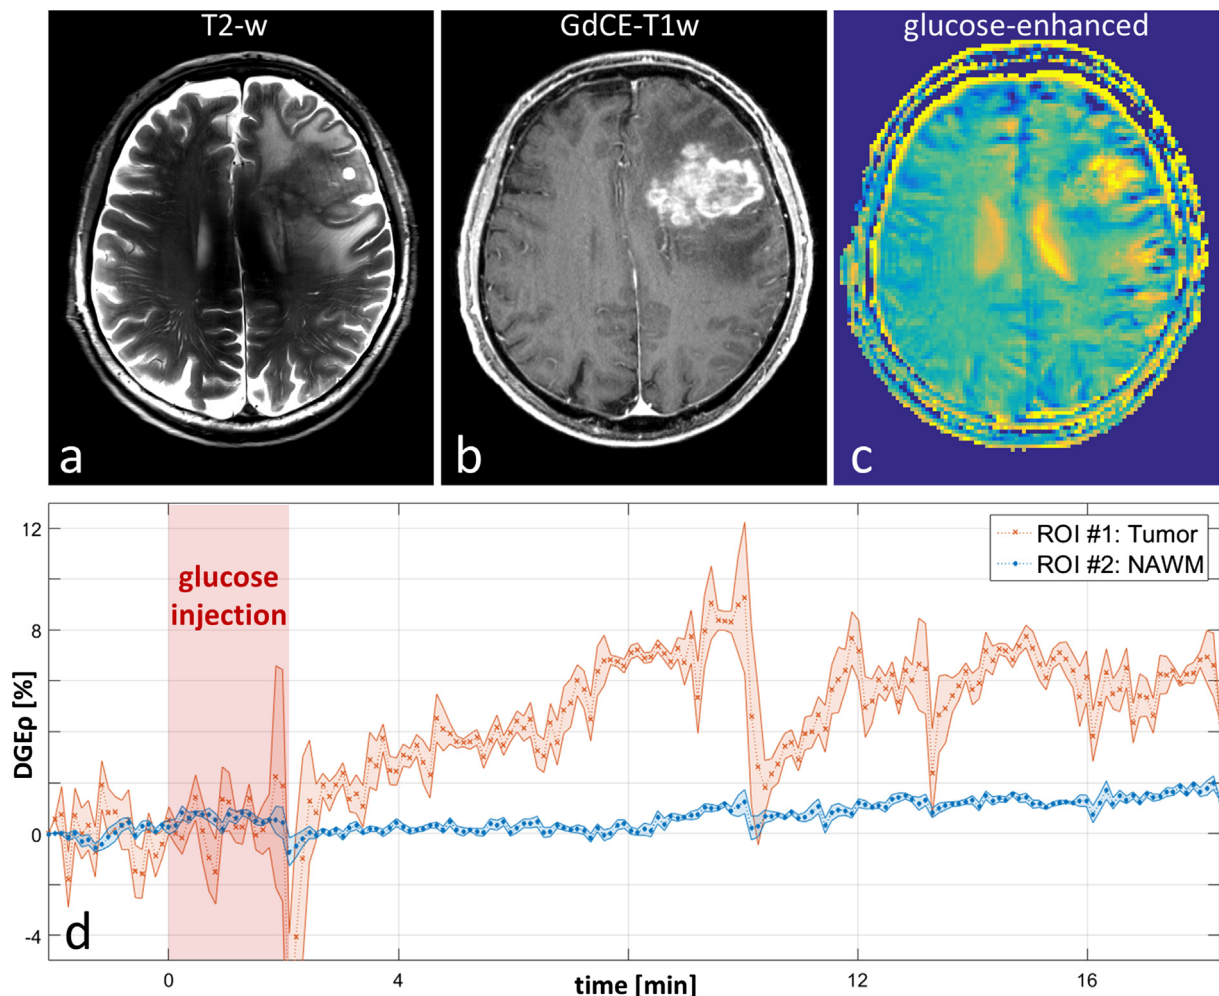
(a) T2-weighted image acquired at 7 T, (b) gadolinium-enhanced T1-weighted (GdCE-T1w) image acquired at 3 T, and (c) T1p-weighted dynamic glucose enhancement (DGEp) obtained at $t = 588$ s at 7 T. (d) Unsmoothed DGEp time curves with a temporal resolution of better than 7 s in a tumor ROI (ROI #1) and a ROI in normal appearing white matter (ROI #2). The signal drop at $t \sim 10$ min is attributed to subject motion. Reproduced from [540] under the license <https://creativecommons.org/licenses/by/4.0/>.
